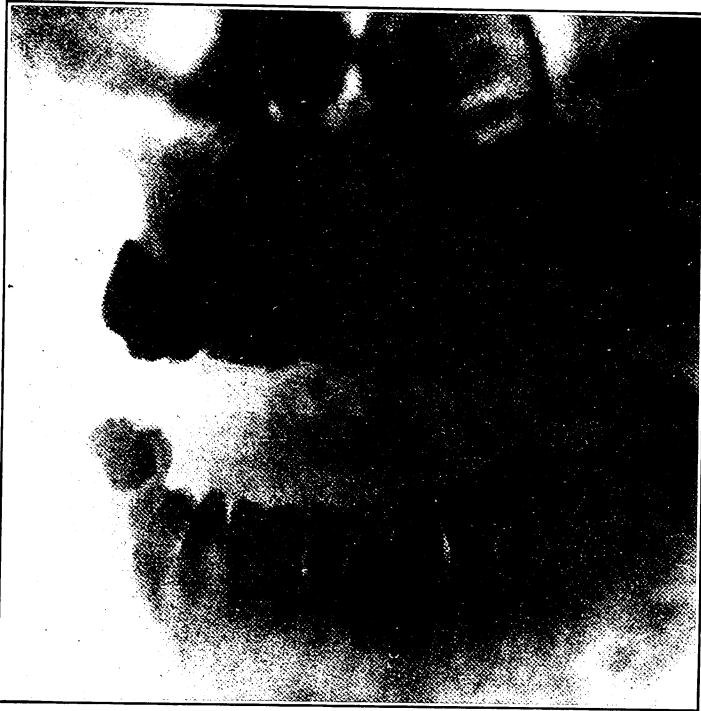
Radiograph made from the pose shown in Fig. 98. Notice how clearly the antra show.
